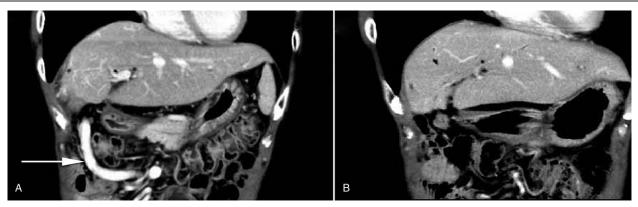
The blood vessel of the jejunal loop disappeared after operation. (A) Preoperative MDCT. White arrow, blood vessel of the jejunal loop, (B) postoperative MDCT. MDCT = multidetector computed tomography.
